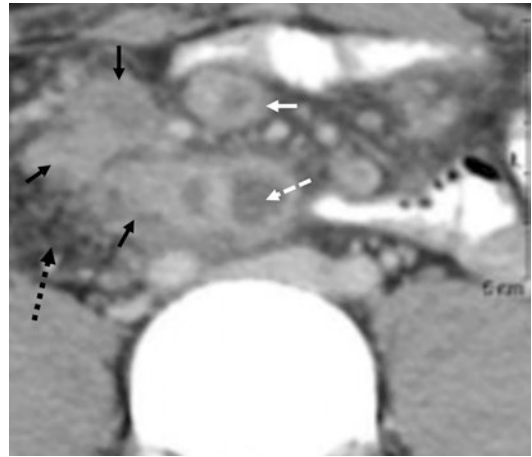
Tuberculous lymphadenitis. Axial contrast-enhanced CT image shows multiple confluent enlarged mesenteric lymph nodes (black arrows) with associated perinodal fat stranding and cloudiness (dashed black arrow). Caseation in the center of the enlarged lymph nodes shows low density (dashed white arrow) due to insufficient blood supply, while peripheral inflammatory lymphatic tissue shows higher density due to preserved blood supply and enhancement (white arrow)
